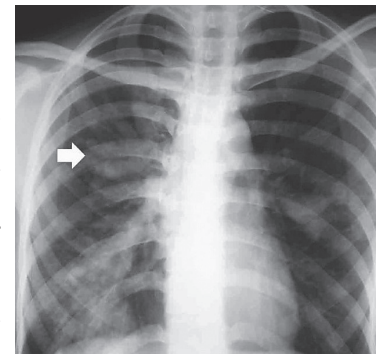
Chest radiography showed mucoid impaction with the classic finger in glove pattern.
